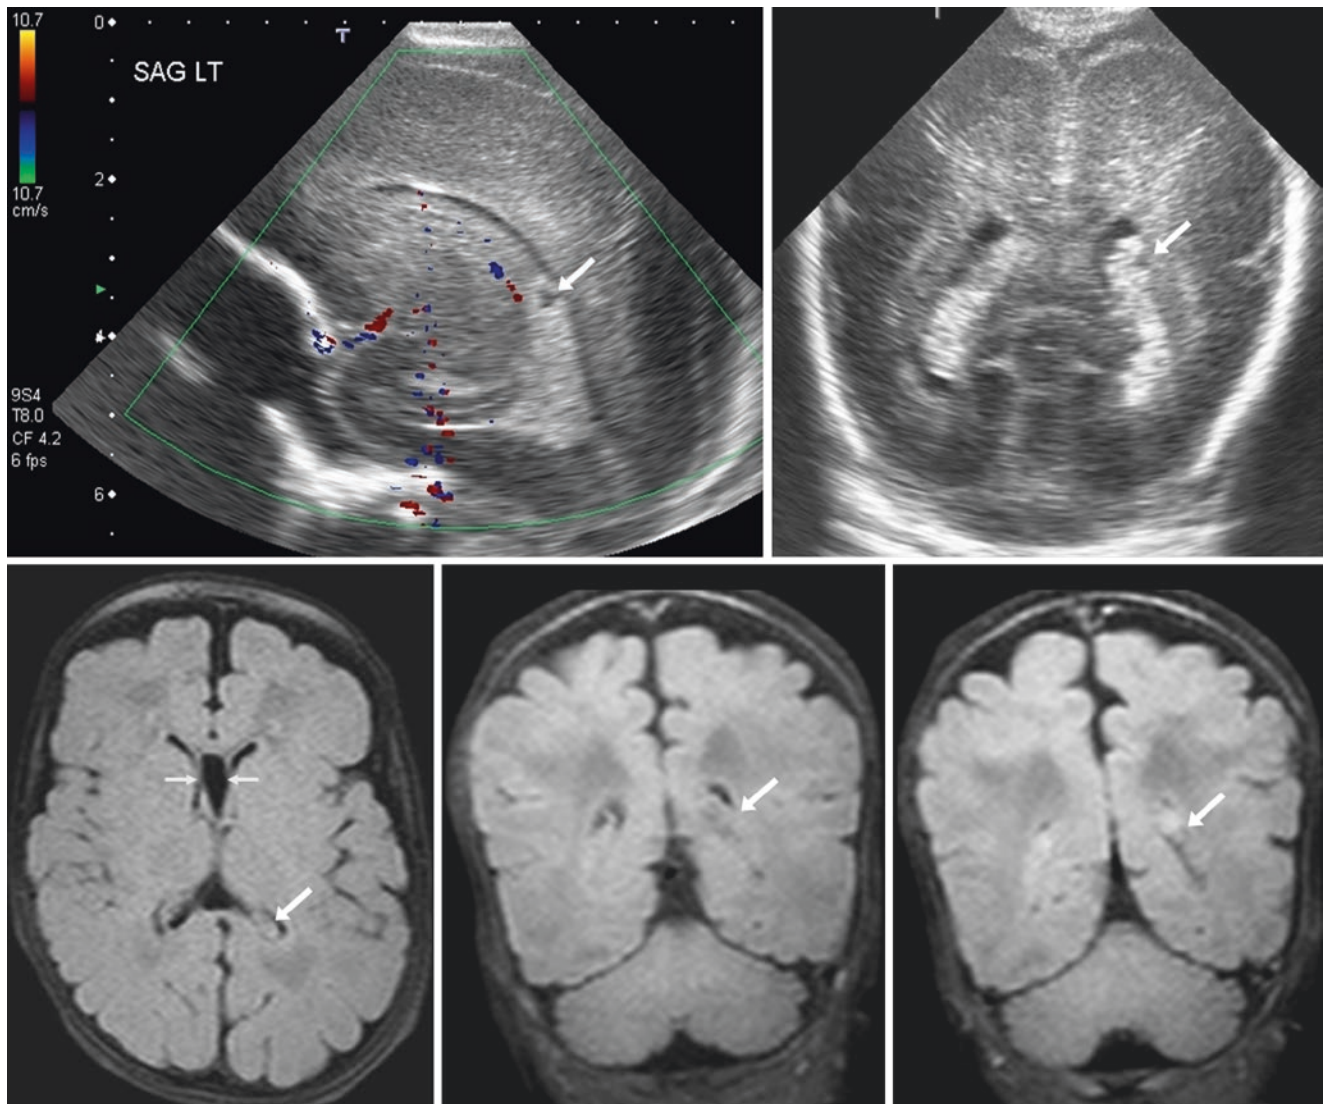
A 10-day-old premature infant (26 weeks' gestational age at birth) with a 2.5-mm CPC (arrows) within the left lateral ventricle on sagittal (*top left*), and coronal (*top right*) US images. No other findings were noted; the patient did not have a syndromic abnormality. On a 3 T MRI at term-equivalent age (about 3 months postnatal), the cyst was not
